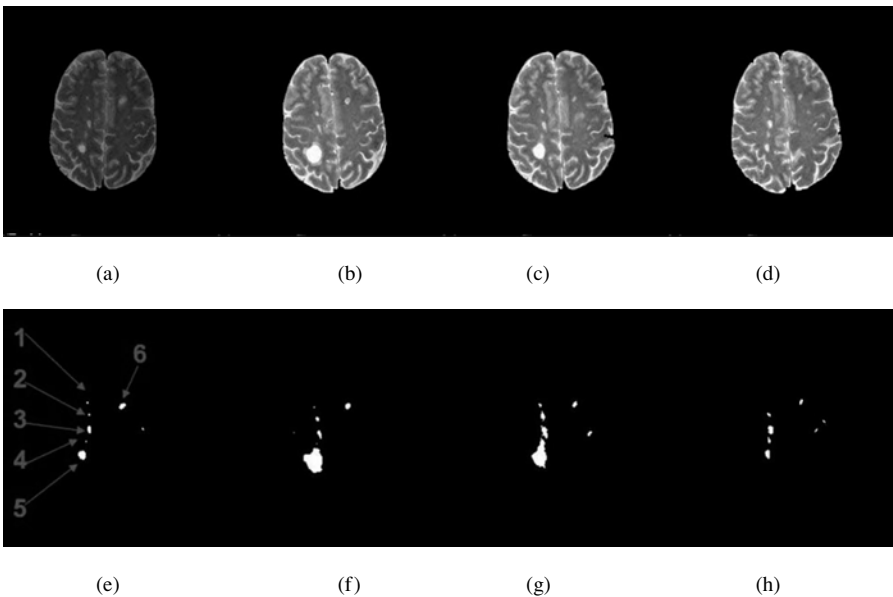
MR images with MS lesions in chronic order, segmentation and labeling.
